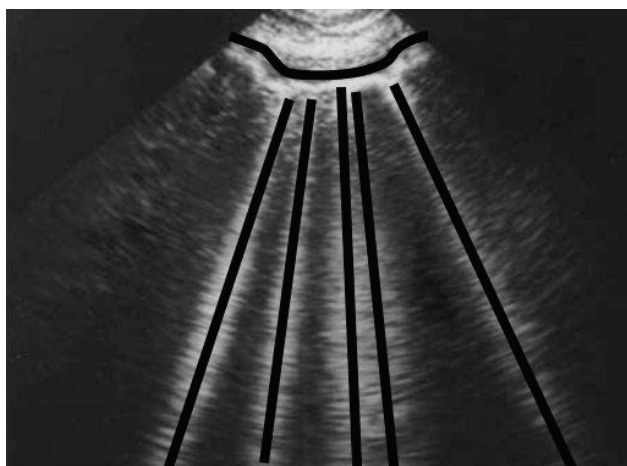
Lung ultrasound with visible B lines. Bat sign marked with horizontal curved black line; B lines highlighted with straight vertical lines (Modified image, original image by Lichtenstein et al. ¹², Creative Commons License 2.5).
